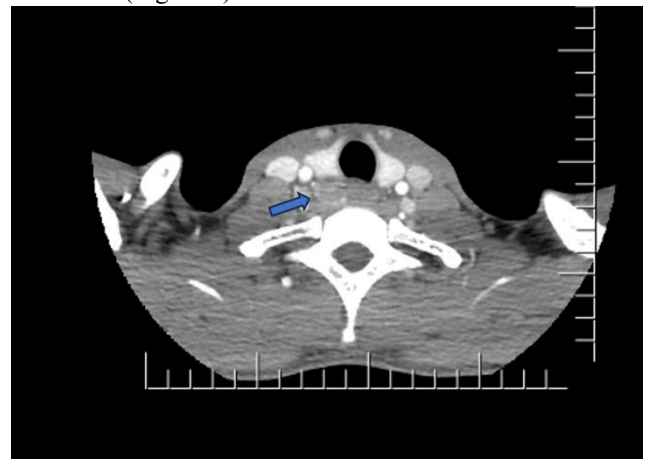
Axial contrast-enhanced CT image (soft tissue window) of the neck revealing a well-defined, enhancing lesion (arrow) inferior to the right thyroid lobe, consistent with a suspected parathyroid adenoma
